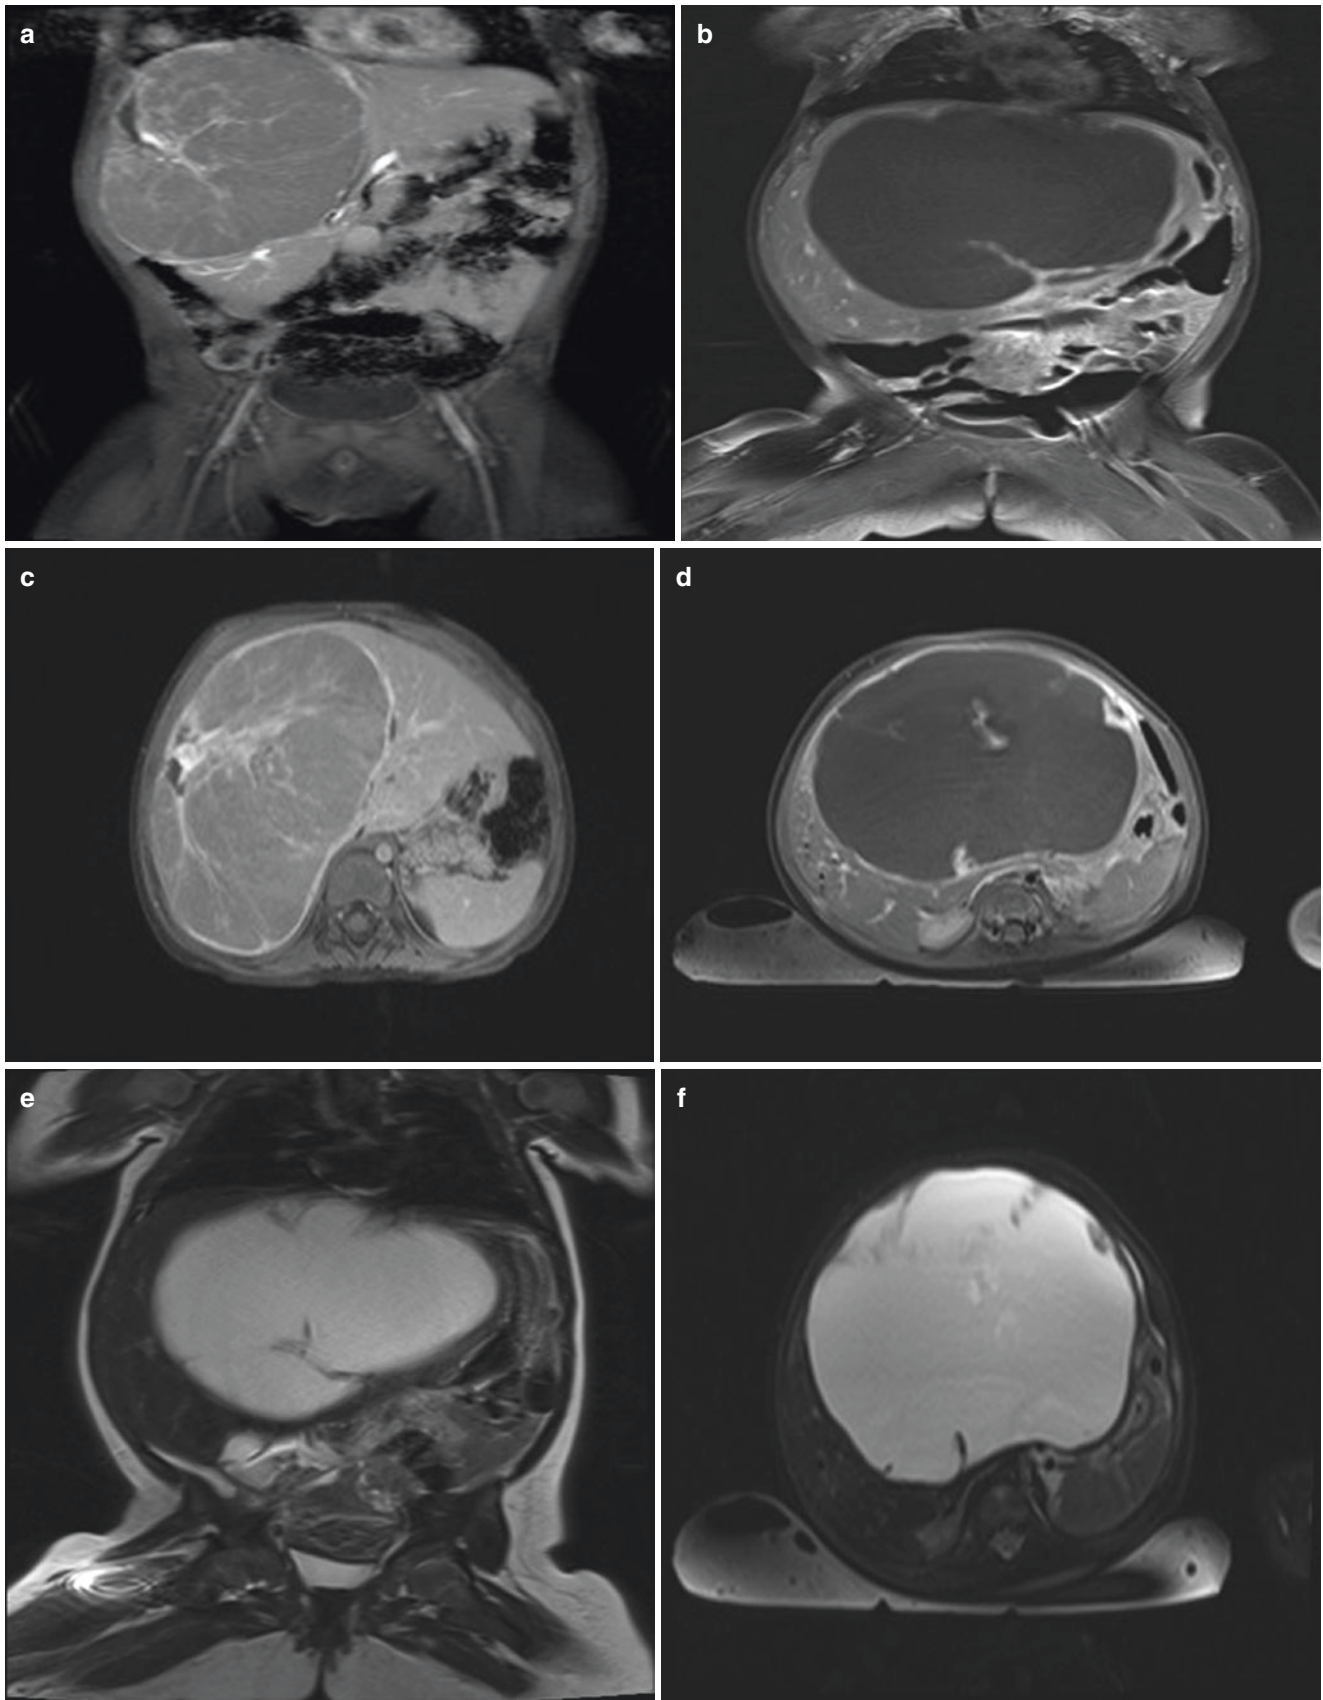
(a-f) Mesenchymal Hamartoma MRI scan-T1 post gadolinium enhanced fat-sat coronal and axial images reveal large cystic lesion with thin enhancing septae and involving the entire right lobe of liver
